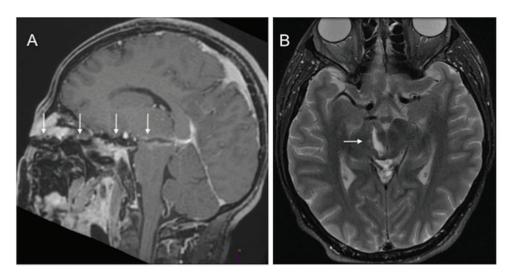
Brain Magnetic Resonance Imaging. (A) Post-contrast volumetric T1 with sagittal oblique reformation showing the knife trajectory reaching the midbrain. (B) Axial T2 image showing the right midbrain lesion.
